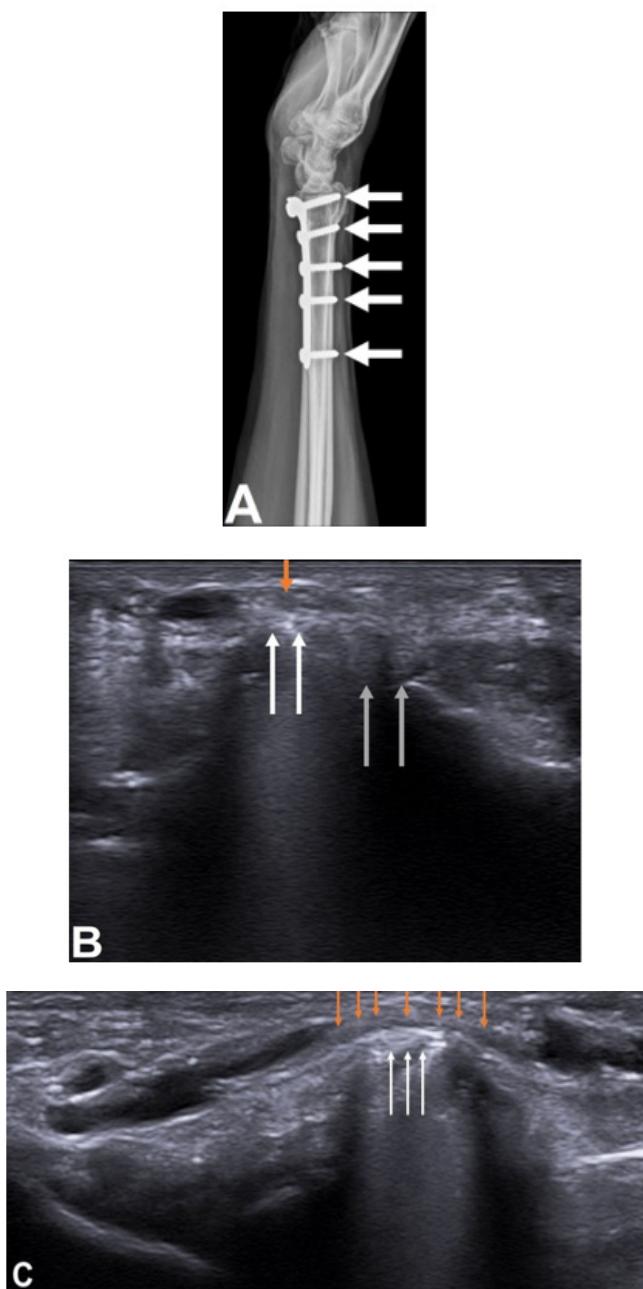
Right wrist lateral radiograph (A) showing volar plate and metal screws with involvement of the dorsal cortex by the metal screws (white arrows). Right wrist axial (B) and sagittal (C) ultrasound detecting the metal screw compromising the dorsal cortex of the radius (white arrow), compressing the radial nerve (orange arrows) and impacting the extensor pollicis brevis tendon (gray arrows).
